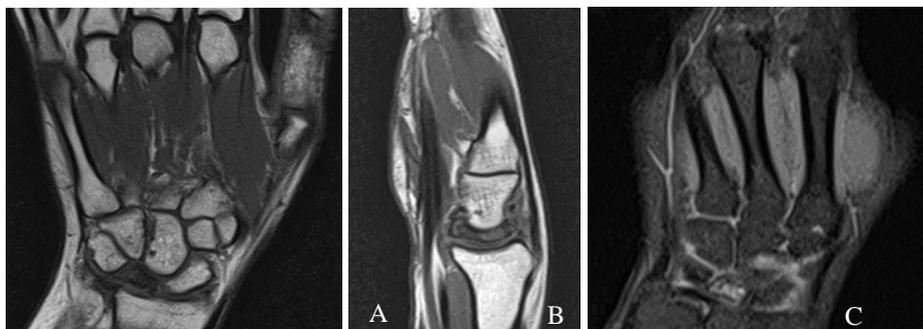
MRI of the wrist (A: coronal T1 weighted image, B: sagittal T1 weighted image, C: coronal DP FS image) showing a collapsed lunate with hypointense T1 signal and hyperintense DP Fat-Sat signal
